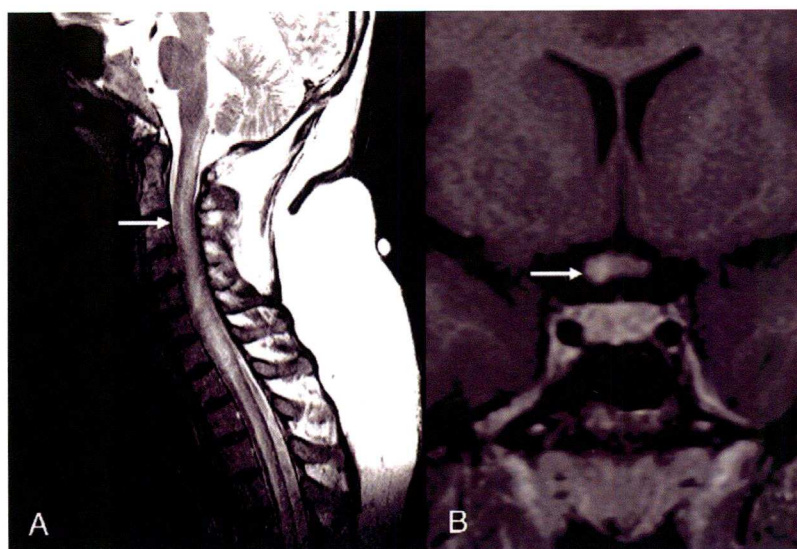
T2 weighted cervical spinal cord MRI in a patient with NMO showing a longitudinally extensive (>3 vertebral segments) lesion (arrow). 1B: Coronal T1-Weighted brain MRI of NMO patient showing enlargement and gadolinium enhancement of the right side of the optic chiasm (arrow).
